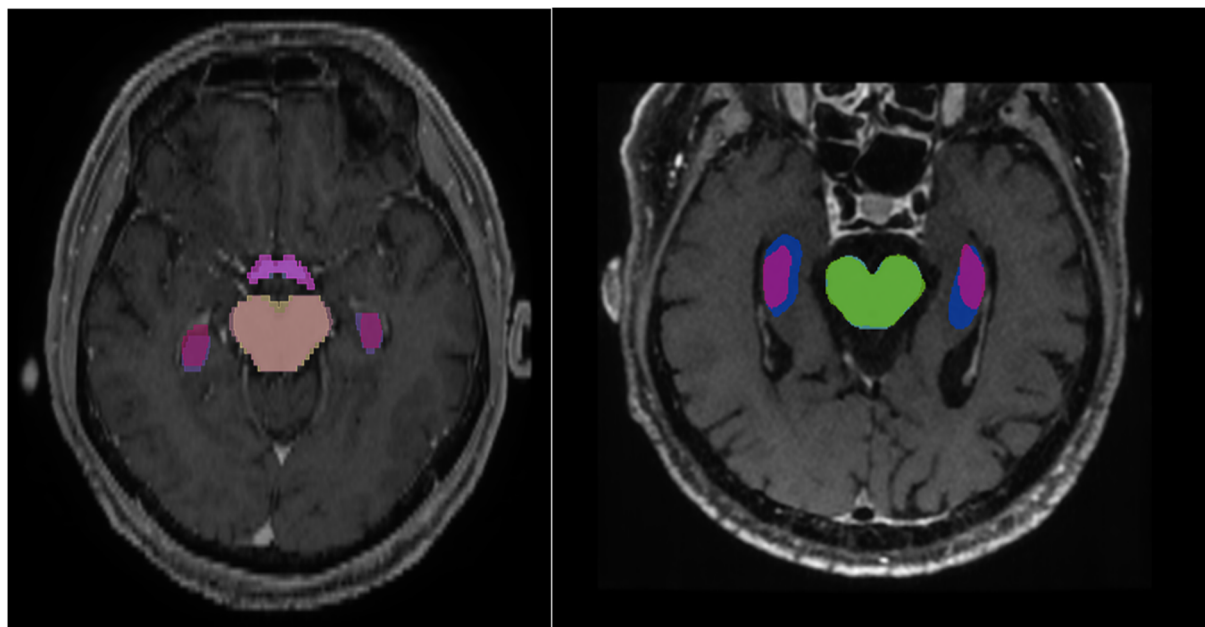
Overlaying contours of anatomical structures built on the original noisy MRI images (old contours) and on denoised images (updated contours)
